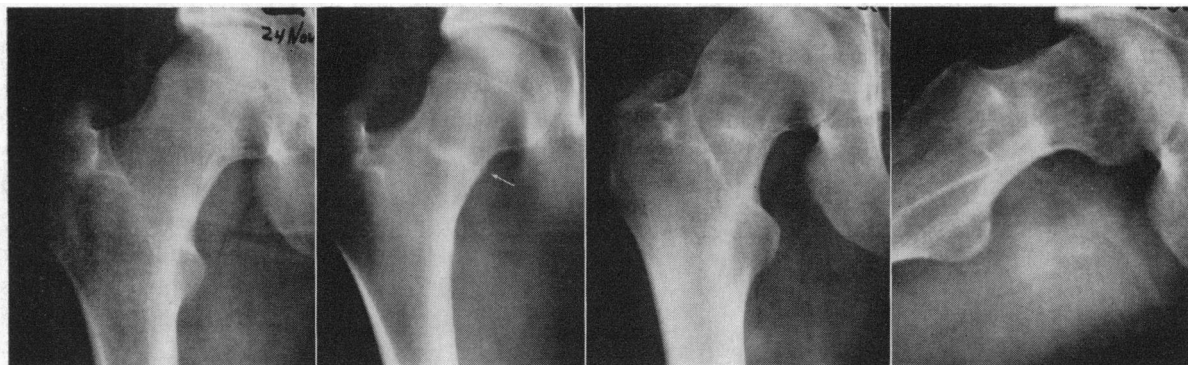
Right hip of a 24-year-old recruit with a history of pain in the right hip which had lasted approximately ten days. Reading from left to right are: Initial x-ray film, interpreted as normal; tomogram of the hip three and a half weeks later, demonstrating fatigue fracture of the femoral neck (arrow) with endosteal and slight periosteal callus; anteroposterior and lateral views nine days later when the patient was asymptomatic.
